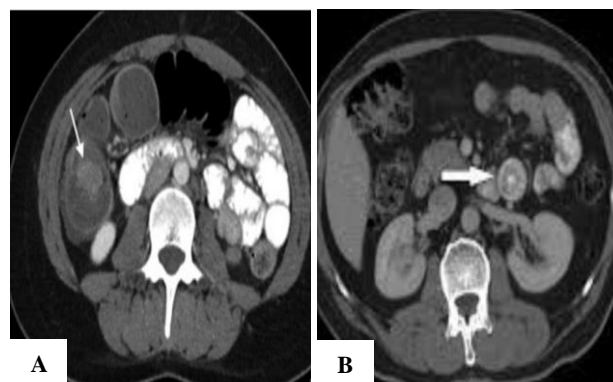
(A) CT scan of 13 year male showing ileo-colic intussusception (arrow) as causing obstruction and (B) CT scan of 40 year male showing 40 year target sign (arrow) in ileo-ileal intussusception.
